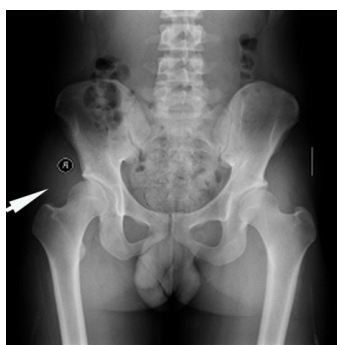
X-ray examination showed no obvious ossification of the right buttock.
